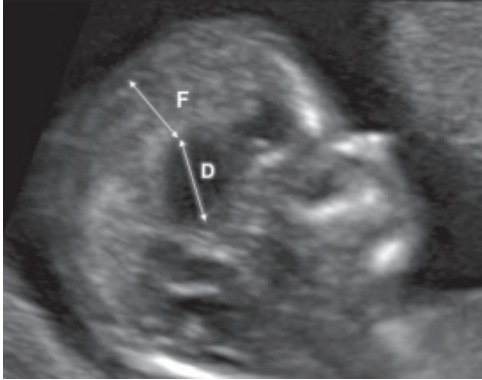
Agenesis of corpus callosum in midsagittal ultrasound view in first trimester, showing increased ratio between diencephalon (D) and falx (F) diameters. In 80% of fetuses that had agenesia of the corpus callosum diagnosed later in gestation, there was an increased ratio between the diencephalon diameter (from midbrain to falx, including third ventricle and thalami) and the falx diameter. Adapted from Volpe et al. 2021.
